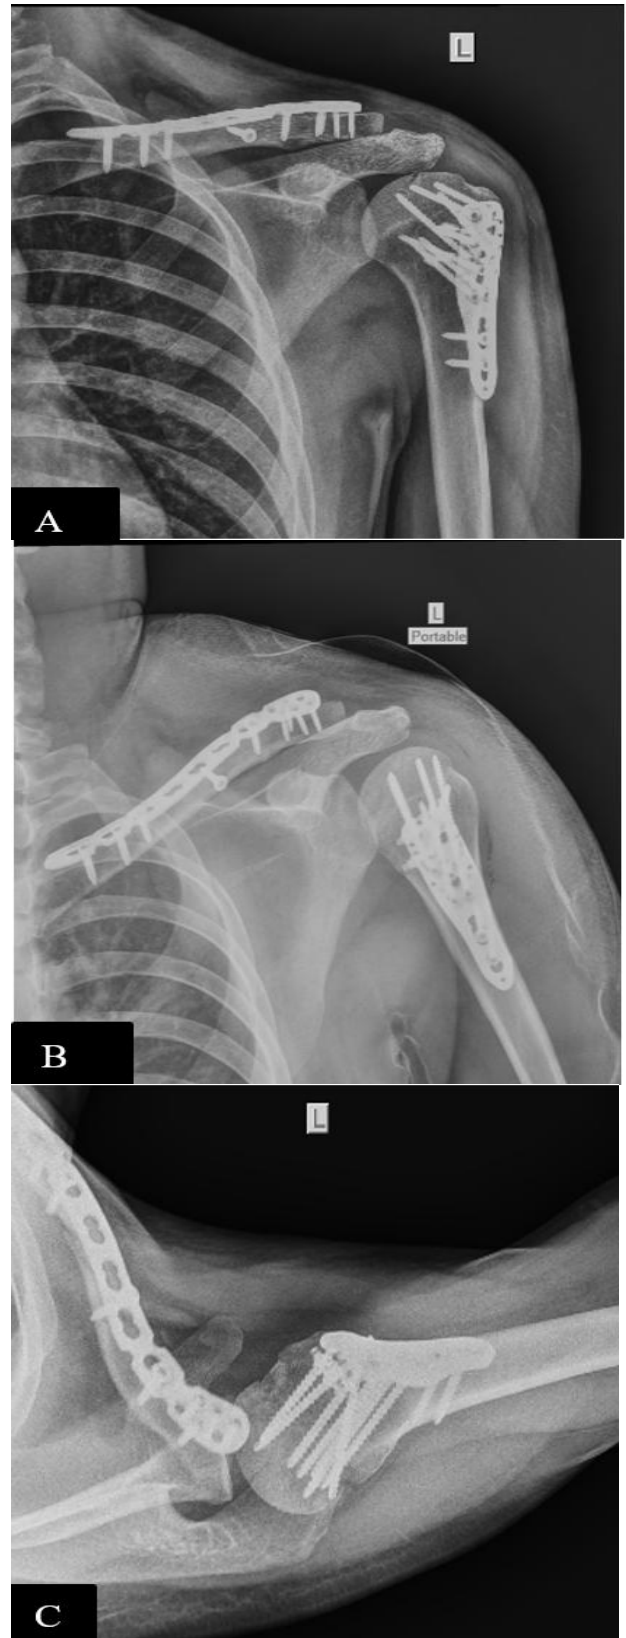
Post operative X-rays (A) AP view (B) Lateral view (C) Axillary view showing well reconstructed proximal humerus and clavicle fracture, a congruent shoulder joint articulation with implants *in situ*.
